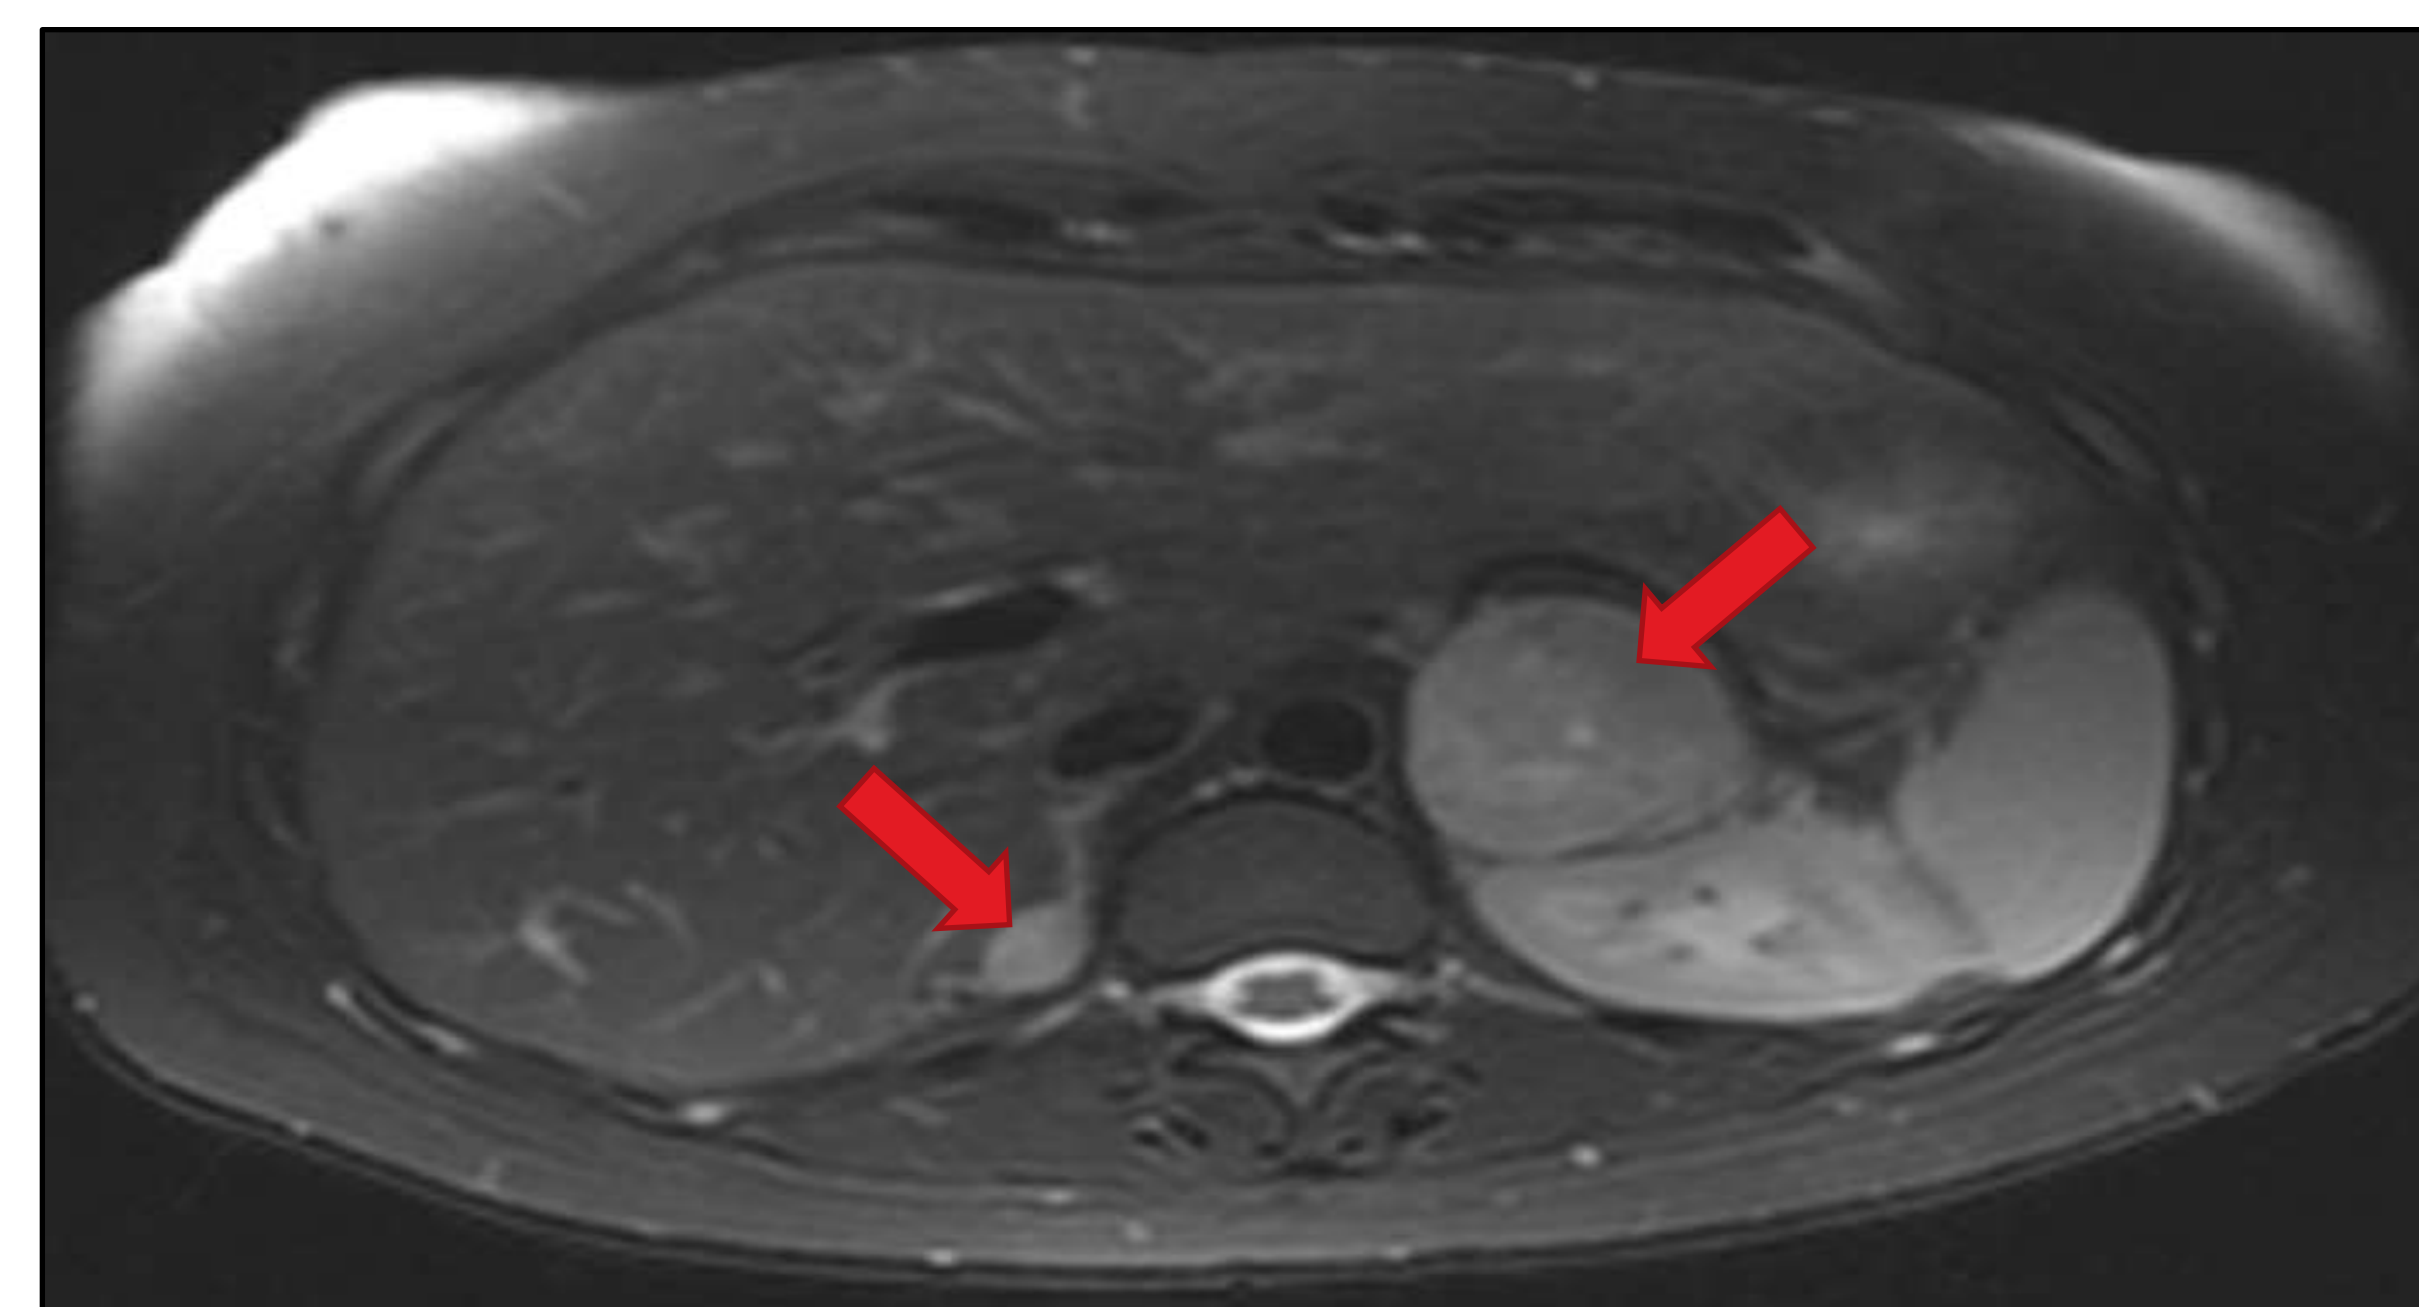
CT Scan of bilateral pheochromocytoma (arrows) in a patient with MTC. Pheochromocytoma is present in approximately 50% of MEN2A and MEN 2B patients.
